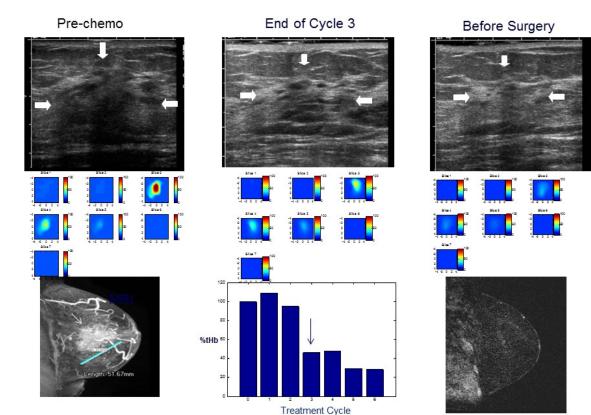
An example of pCR who had a HER2 positive tumor. 55-year-old woman with an intermediate grade invasive ductal carcinoma treated with Herceptin-based regimen. Top panel: US images at three time points. The tumor was ill-defined and heterogeneous seen by US, and was palpable at the beginning of the treatment. Middle panel: total hemoglobin concentration maps obtained at the three time points. Each map shows 7 sub-images marked as slice 1 to 7 and each sub-image shows spatial x and y distribution of tHb concentration reconstructed from 0.5 cm to 3.5 cm depth range from the skin surface. The spacing between the sub-images in depth is 0.5 cm. The tHb reduced from 113 μ mol/L measured at pretreatment or baseline to 33 μ mol/L measured before surgery (71% reduction). Dramatic reduction occurred at the end of cycle 3 (55% reduction) (middle column of Bottom panel). Bottom panel: MRI images before (left) and after treatment before surgery (right). The MRI measurements were 3.2 x 4.8 x 5.2 cm before treatment with no visible residual tumor at the end of treatment. The percentage ratio is 0% or reduction in largest dimension was 100%. Middle column: total hemoglobin level normalized to baseline (%tHb) vs. treatment cycles. This patient had a complete pathologic response with no residual tumor; her tumor was Miller-Payne grade 5.
